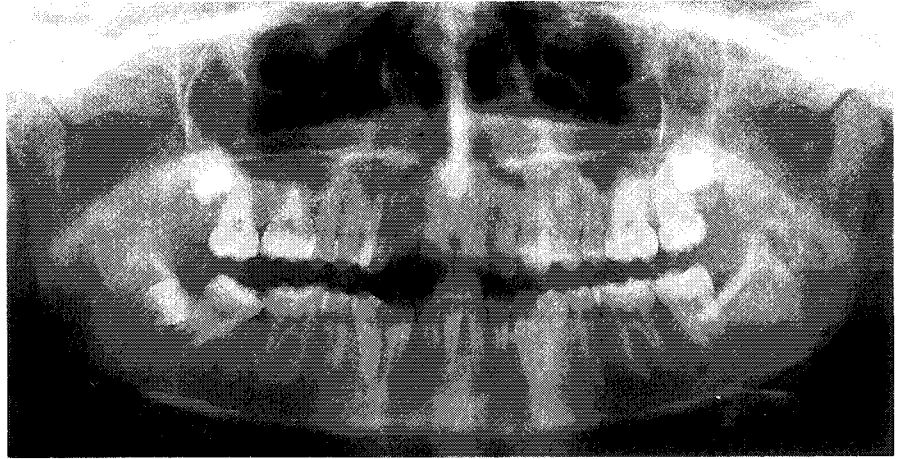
Post-treatment OPG radiograph.
